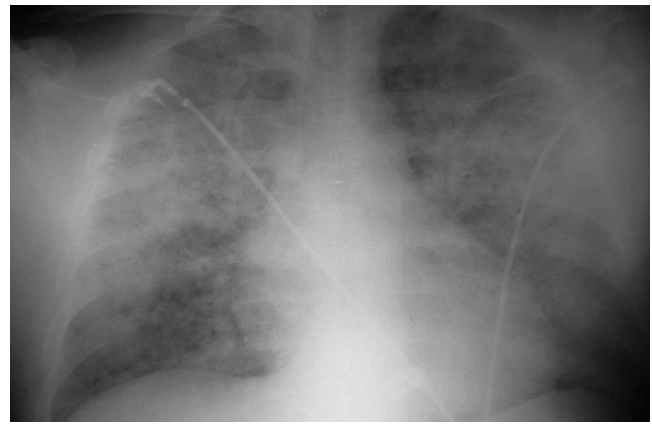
Chest X-ray (2003-09-14) showing significant progression and volume loss in both lungs. A palm-sized homogeneous consolidation developed in the central part of the lung, a marked interstitial enhancement was seen in other parts of the lung. The radiological image suggested ARDS. The heart was enlarged.
